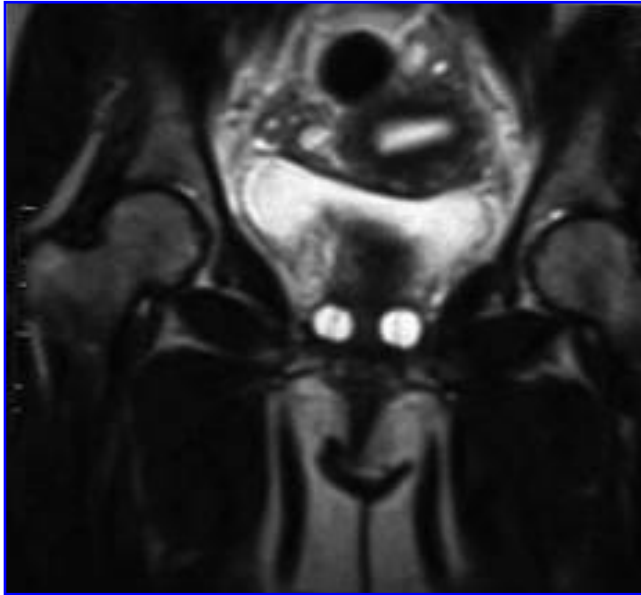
MRI showing ACT balloons in place with Foley catheter.
